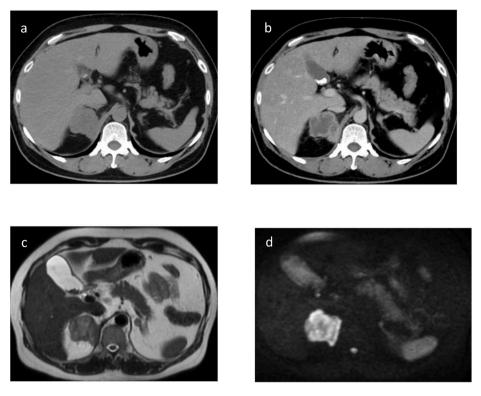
Contrast-enhanced CT showing a right adrenal tumor with a predominant marginal contrast effect (a: non-contrast CT; b: contrast-enhanced CT). MRI shows a heterogeneous signal in the enlarged right adrenal gland on T2-weighted images (T2WI) and high signal with marginal predominance on diffusion-weighted images (DWI). (c: T2WI, d: DWI).
